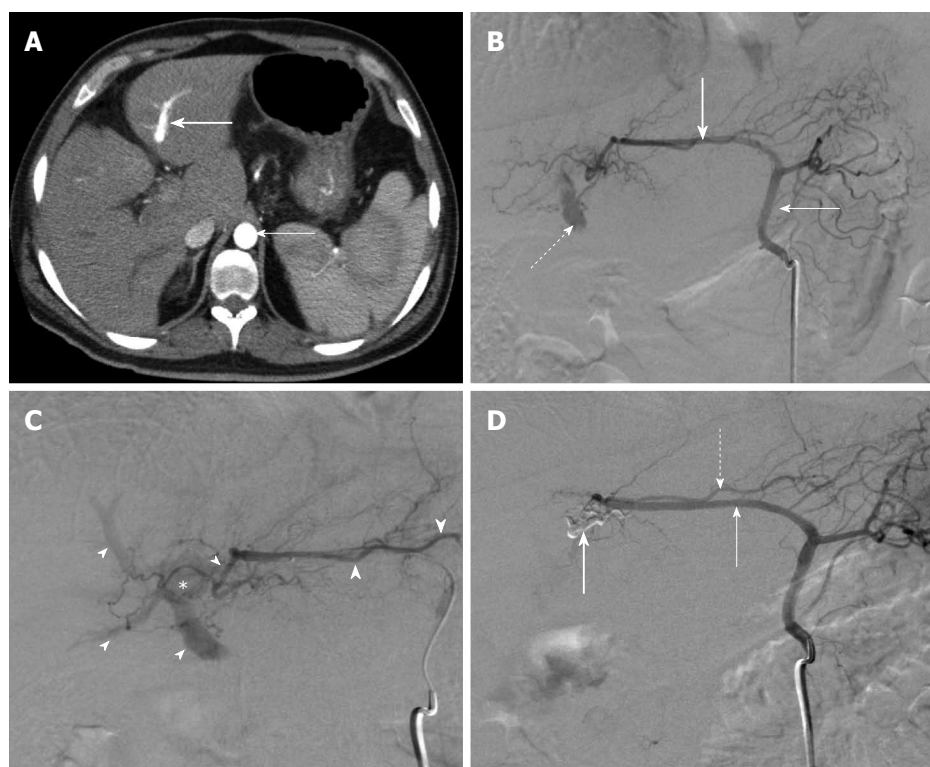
Intrahepatic communication between hepatic artery and portal vein. A: Contrast enhanced axial computed tomography of the abdomen demonstrating similar contrast opacification of the aorta (thin arrow) and the left portal vein (thick arrow); B: Left gastric arteriogram demonstrates gastrohepatic trunk (thin arrow) giving rise to aberrant left hepatic artery (thick arrow). Note early opacification of the portal vein (dashed arrow); C: Selective arteriogram with coaxial microcatheter in the left hepatic artery demonstrates medial branch of the left hepatic artery (large arrowheads) contributing to a parenchymal blush (star) and leading to opacification of the portal veins (small arrowheads). Note the normal appearance of the lateral branch of the left hepatic artery (thick arrow); D: Post-embolization arteriogram in the gastrohepatic trunk demonstrates opacification of the left hepatic artery (thin arrow). Onyx cast (thick arrow) is seen occupying the previously seen medial branch of the left hepatic artery. No further opacification of the portal veins is seen. Note the preserved lateral branch of the left hepatic artery (dashed arrow).
